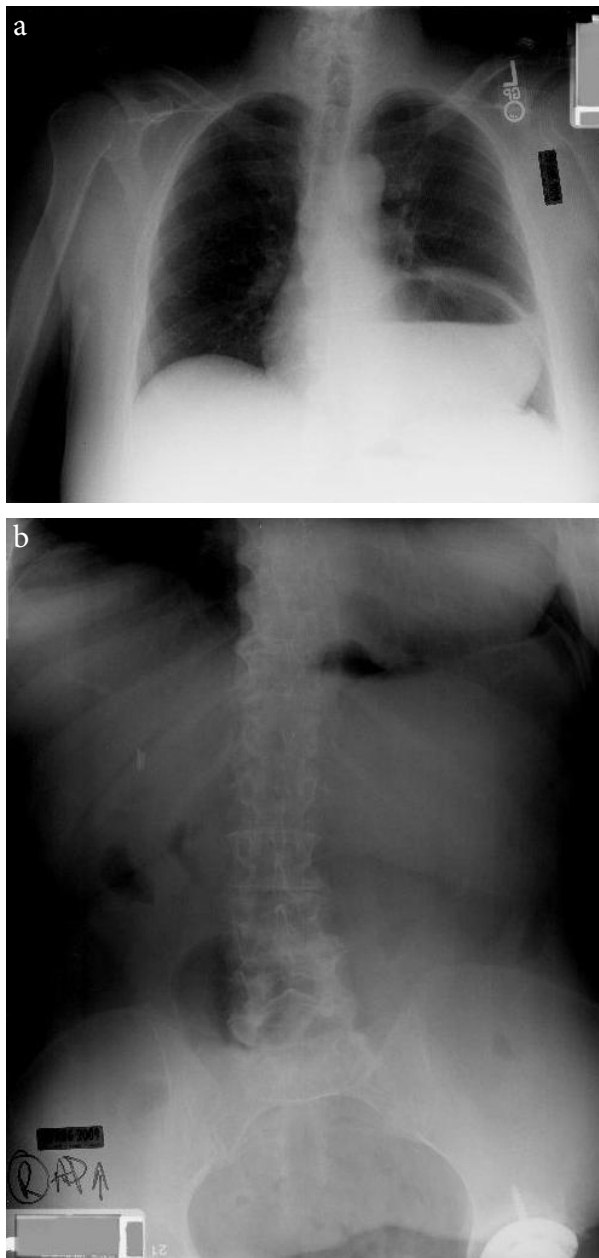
a) Chest x-ray showing stomach shadow in the thoracic area. b) Chest and abdominal radiograph revealing stomach shadow in the thoracic area.
